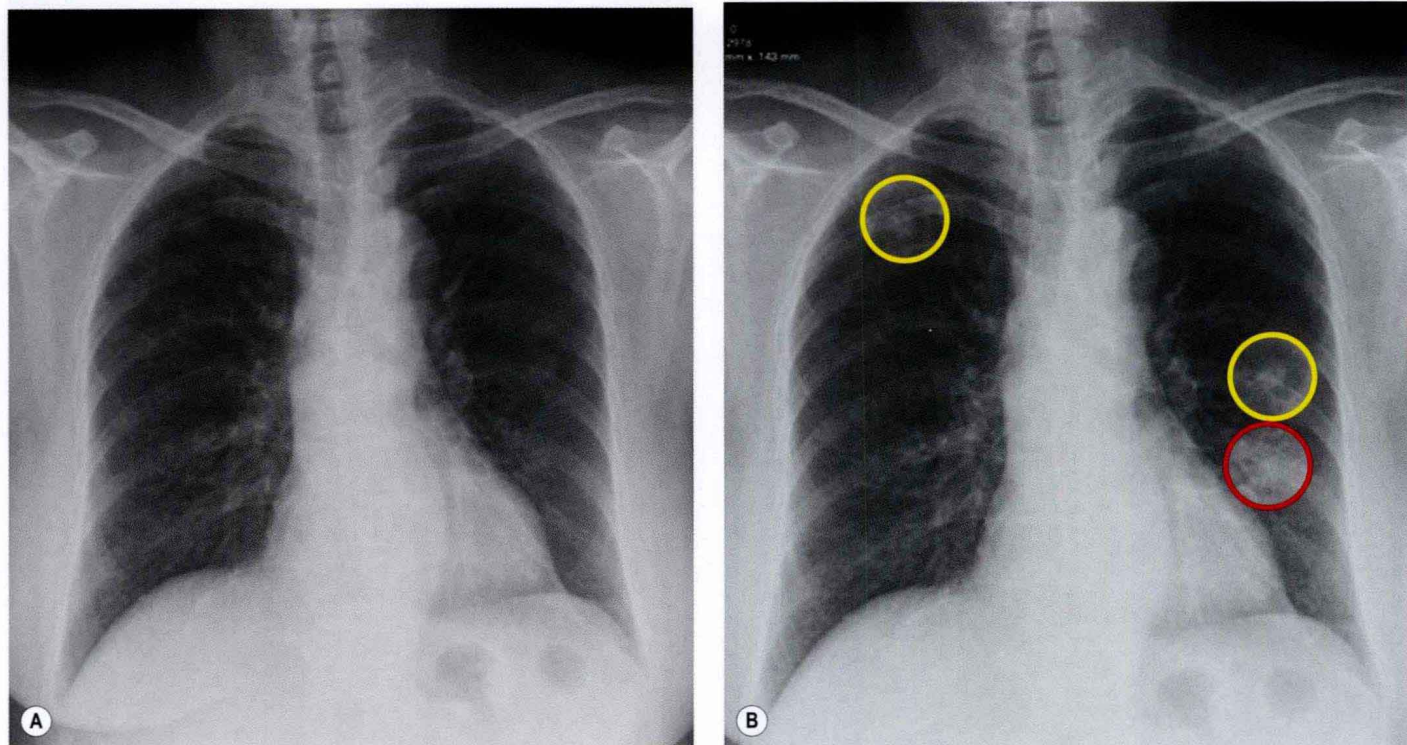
Computer-aided detection (CAD). A, Frontal chest radiograph shows three lung nodules, all of which are successfully detected by CAD shown in B. While two of the nodules are easy to see (yellow circles), one nodule (red circle) is more difficult to detect due to an overlying rib.
